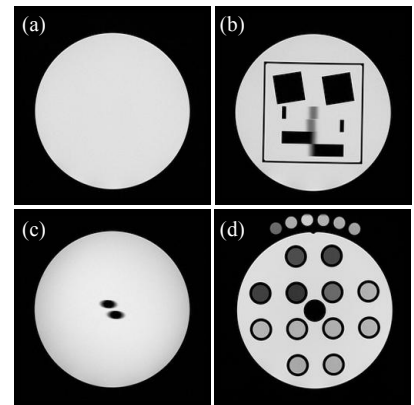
Transversal MRI slice images of the Test Objects (a) TO1, (b) TO2, (c) TO3, (d) TO4 and a set of six tubes
